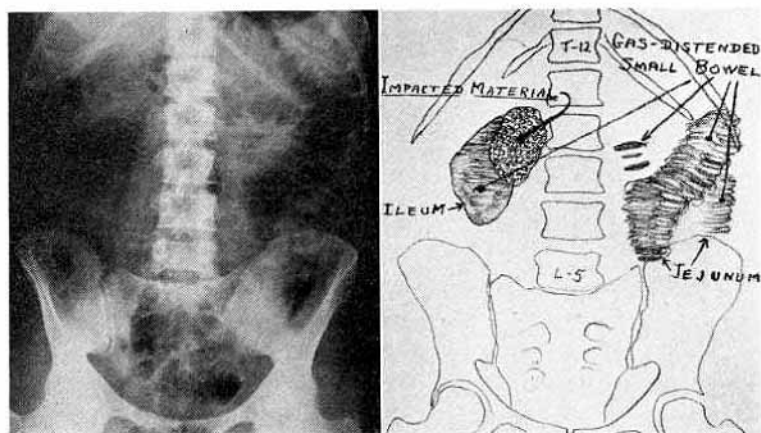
Case I. Mrs. S. E., aged thirty-nine years, ventral projection of the abdomen with patient prone. Note the distended small intestine outlined by gas, the jejunum on the left side of the abdomen showing well-marked valvulae conniventes, the large loop of ileum in the right side of the abdomen identified by the lack of mucosal folds. The patient had a laparotomy three years ago and adhesions are responsible for the present obstruction. They have been present for a long time, without clinical evidence, and the immediate precipitating cause of symptoms is visualized in the roentgenogram and is apparently a large piece of some undigested material, impacted at the site of an adhesion. When this film was made the patient was in great distress, with all the signs and symptoms of intestinal obstruction.
